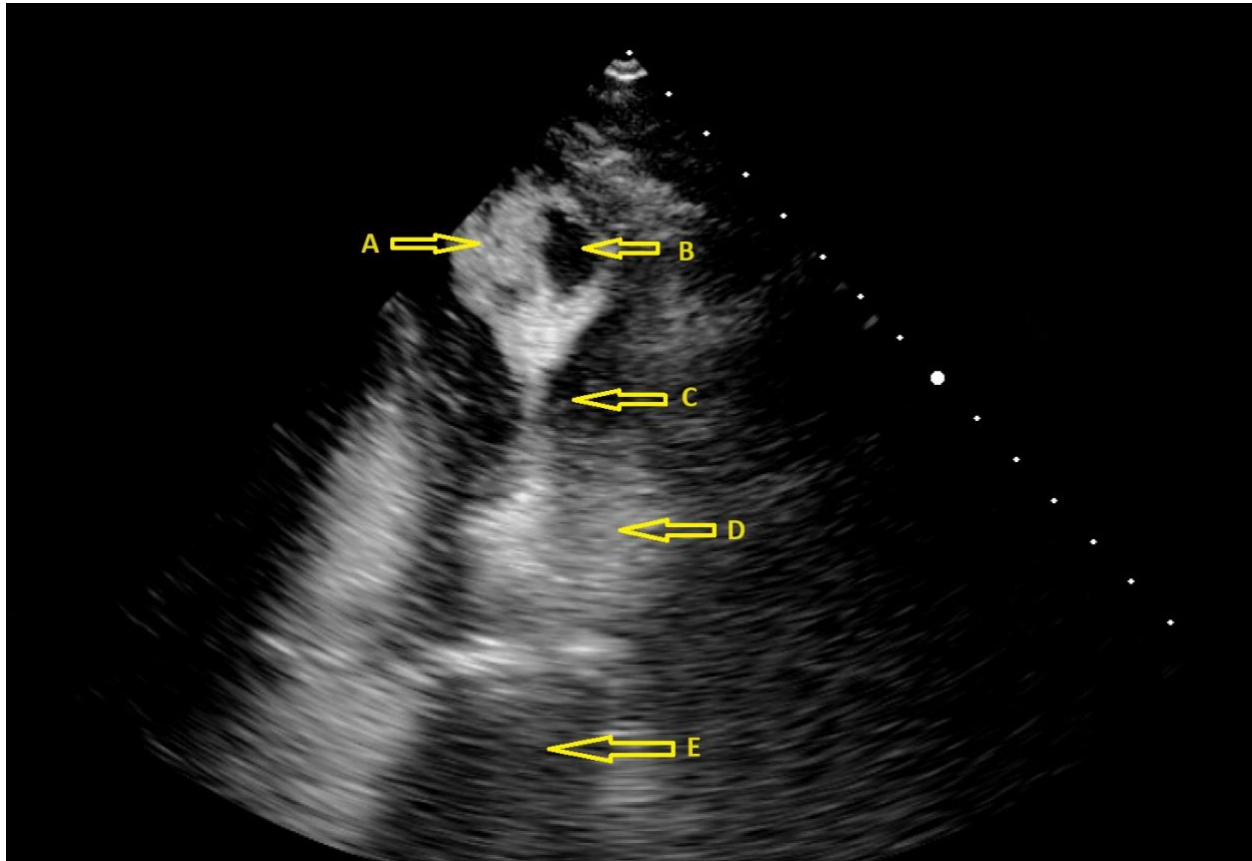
Transthoracic Echocardiogram With Contrast (A) Left Ventricular Apical Aneurysm. (B) Thrombus. (C) Midcavity Left Ventricular Obstruction. (D) Left Ventricle. (E) Left Atrium.
